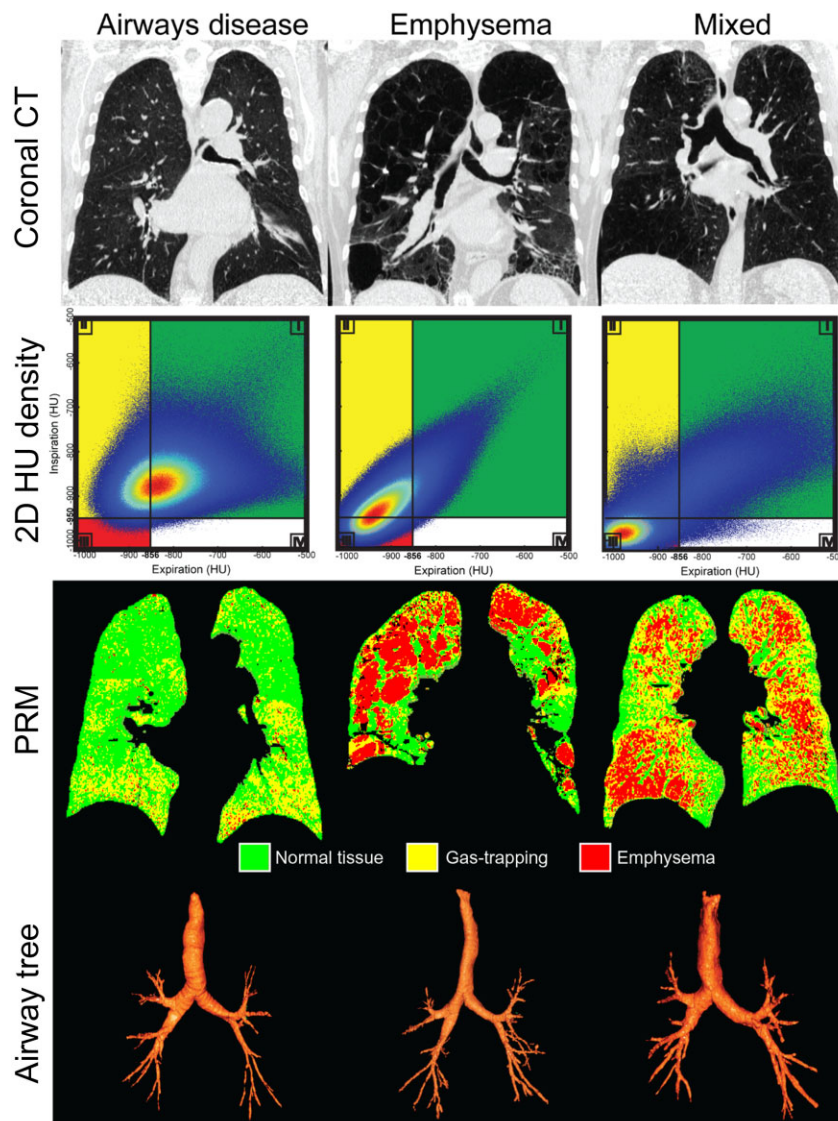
Functional thoracic X-ray computed tomography images. Coronal CT, Hounsfield Unit density plots, parametric response maps (PRM), and reconstructed CT airway trees are shown below. From left to right: airways disease dominant, emphysema dominant and mixed phenotype. Airways disease dominant: WA = 64%, PRM Normal Tissue = 73%, PRM Gas Trapping = 26%, PRM Emphysema = 1%; Emphysema dominant: WA = 63%, PRM Normal Tissue = 42%, PRM Gas Trapping = 17%, PRM Emphysema = 38%; Mixed: WA = 59%, PRM Normal Tissue = 28%, PRM Gas Trapping = 47%, PRM Emphysema = 24%.
